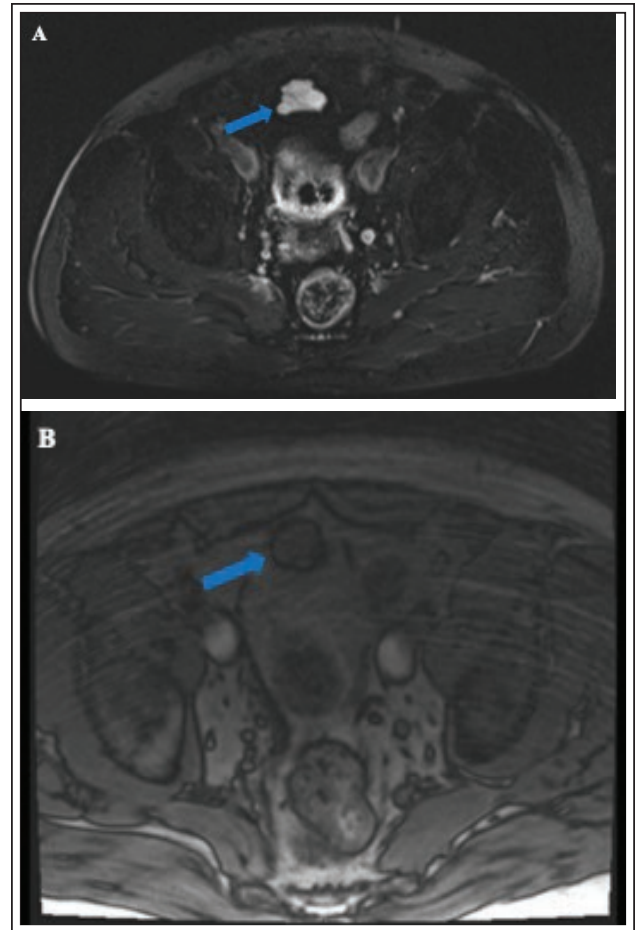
MRI of the abdomen and pelvis demonstrating the urachal lesion at the anterosuperior aspect of the bladder (arrow). A. Axial view, T2 weighted image. B. Coronal view, T1 weighted image with intravenous contrast.
